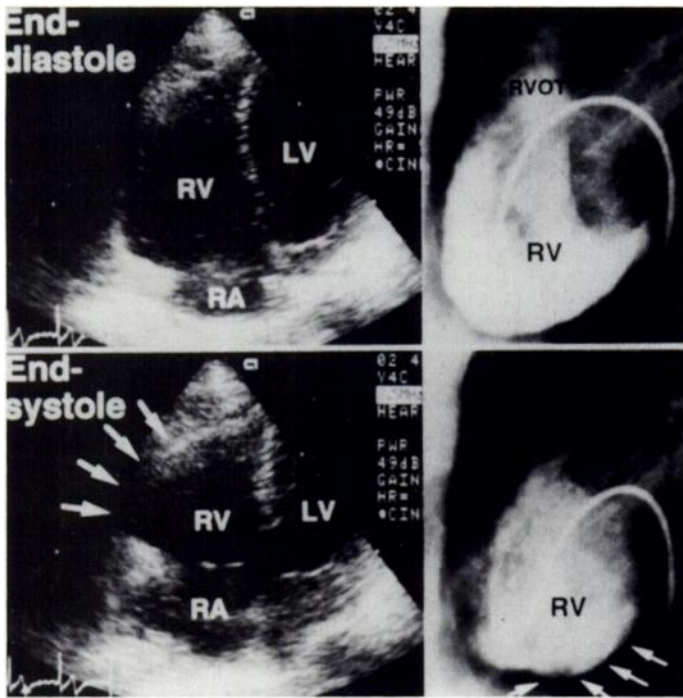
Two-dimensional echocardiograms from the apical four-chamber view (left panels) and contrast right ventriculograms from the left lateral view (right panels) at end-diastole and end-systole demonstrate right ventricular dyskinesia (arrows). LV = left ventricle; RA = right atrium; RV = right ventricle; RVOT = right ventricular outflow tract.
